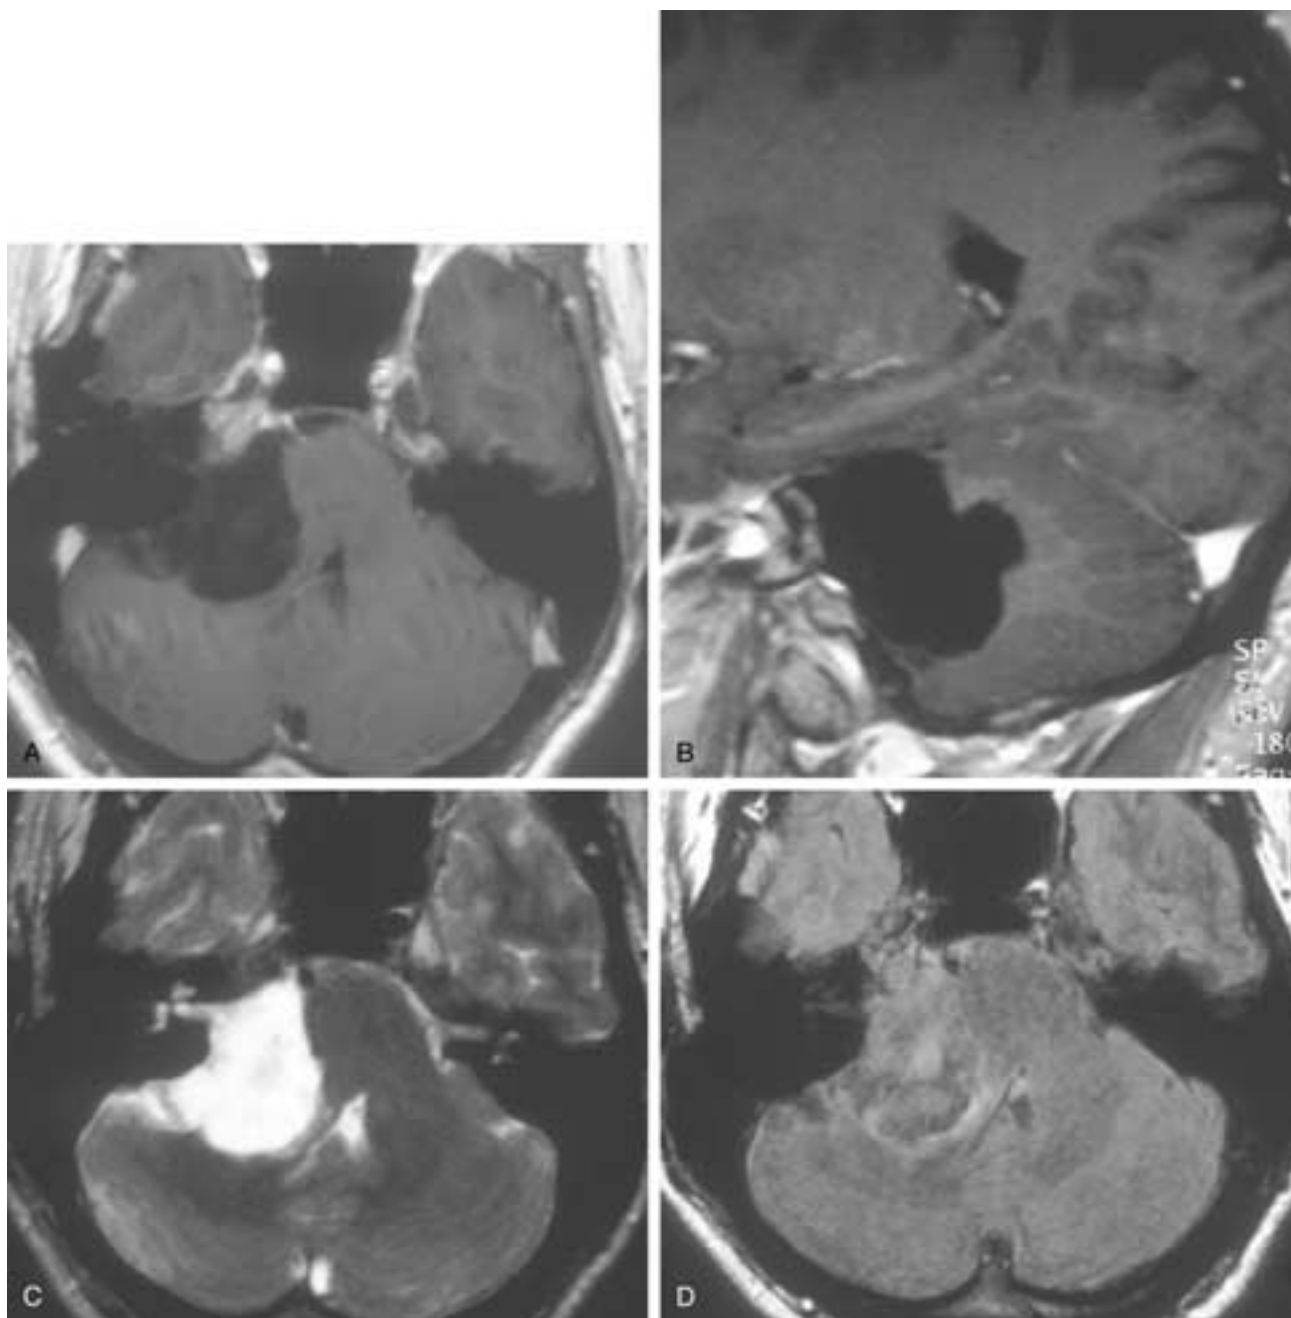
CPA epidermoid. A and B, T1-weighted axial and sagittal images after gadolinium administration. The CPA mass extending to the prepontine cistern is isointense to CSF and shows no enhancement. C, T2-weighted image. The tumor, with irregular, cauliflower-like margins, is isointense to CSF, as in T1-weighted images, and is compressing the fourth ventricle. The IAC is normal. D, FLAIR image. In this sequence the epidermoid has heterogeneous hyperintense foci, enabling differentiation of an epidermoid from an arachnoid cyst in this case.
